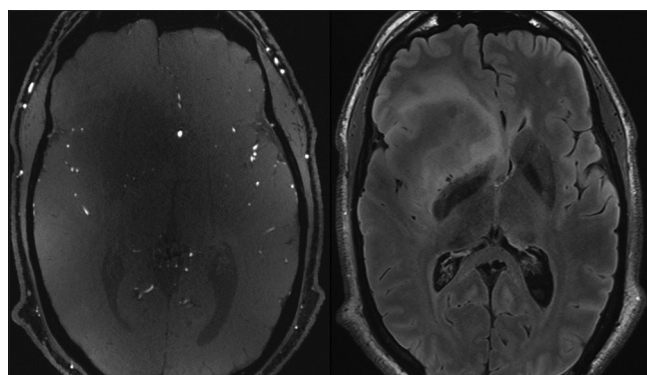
Ultra-high field magnetic resonance imaging: ToF and 3-D FLAIR sequence show the regional vascularization and extension of a right frontal LGG
